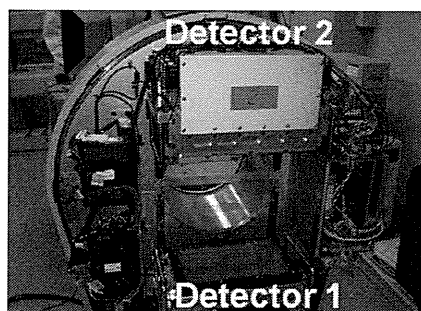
Our high spatial-resolution SPECT system with two high-resolution detectors.
